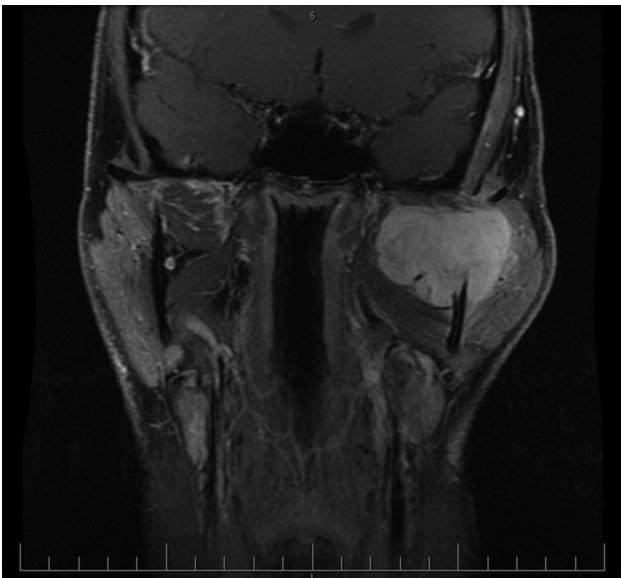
Preoperative imaging. Magnetic resonance imaging coronal view (T1-weighted image post-gadolinium contrast) showing the mass with uptake of contrast agent in the left masticator region.
